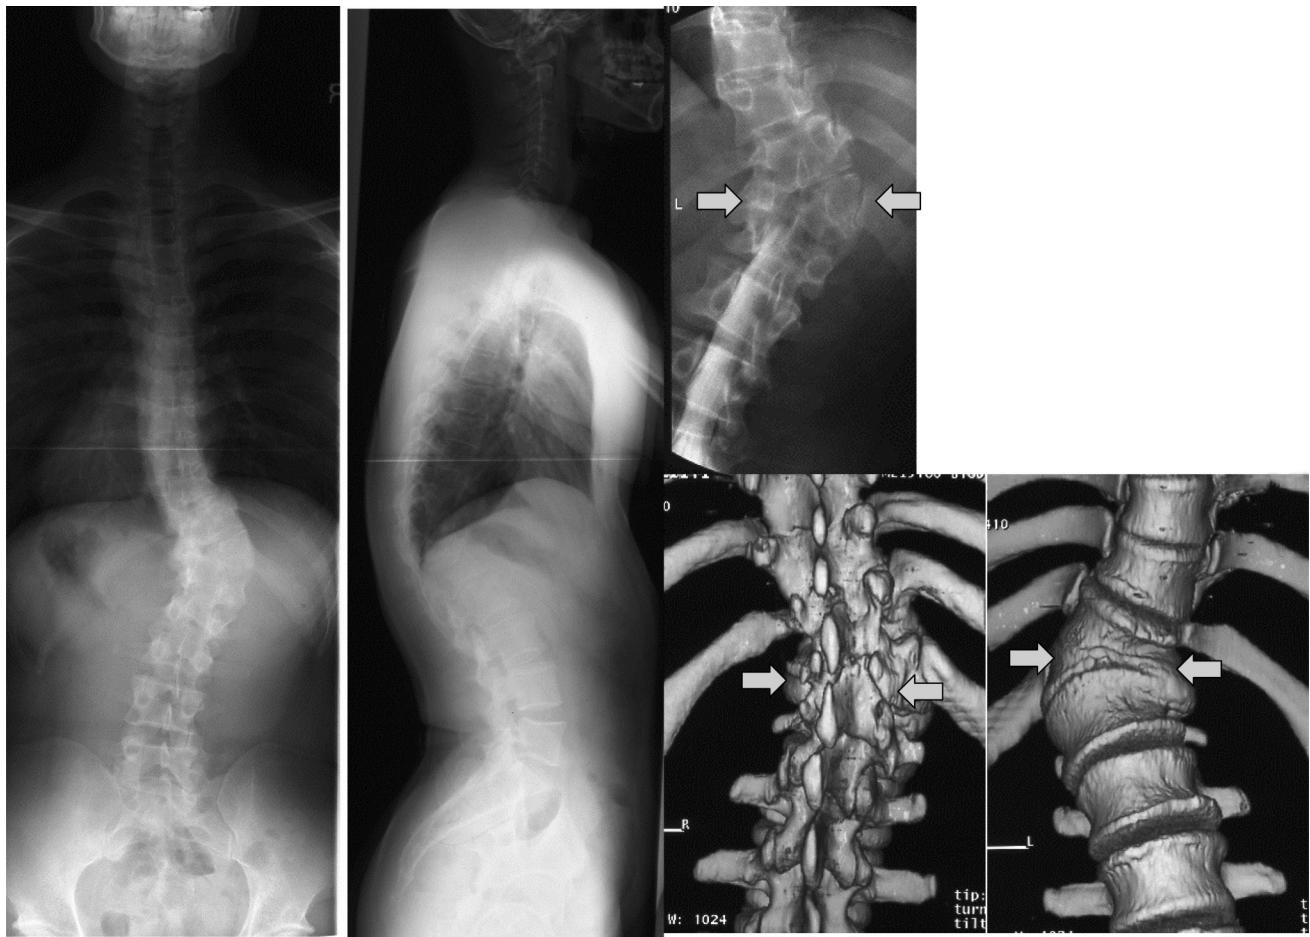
Asymmetrical butterfly vertebra. A 30-year-old man patient complained of lower back pain and numbness of the left lower extremity for more than 5 years. The plain x-ray showed 49° of scoliosis and 50° of kyphosis in the thoracolumbar area. Three-dimensional CT demonstrated an asymmetrical butterfly vertebra of T12 with posterior bilamina (arrow).
